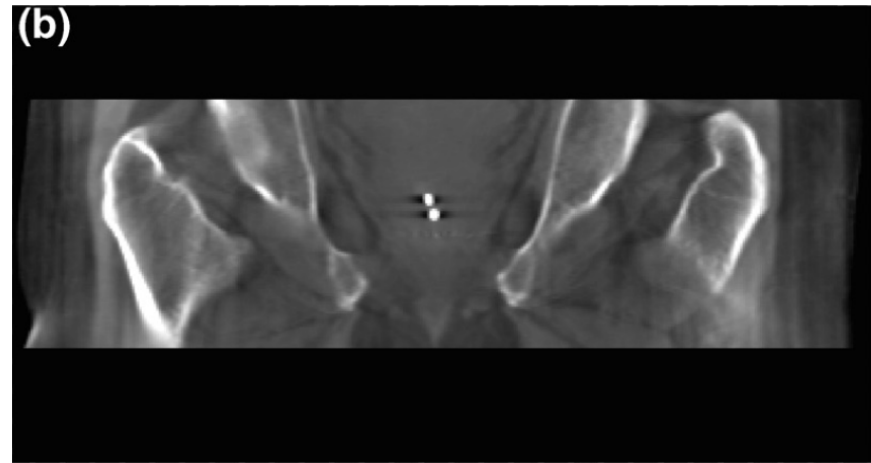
Calcifications shown on (A) planning computed tomography (CT) scan, (B) cone-beam CT scan with standard dose, and (C) cone-beam CT scan with low dose. Blue line indicates prostate contour drawn on planning CT scan.
